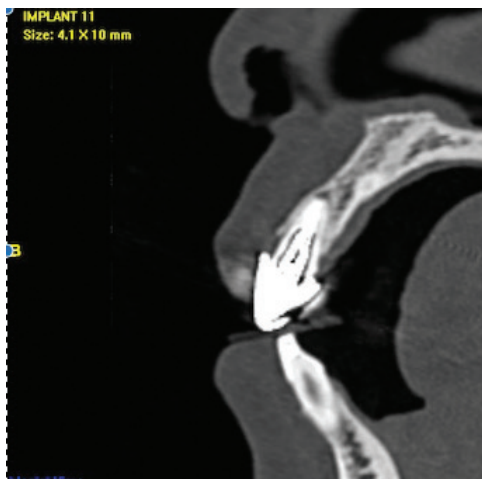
CBCT analysis of maxillary right central incisor
